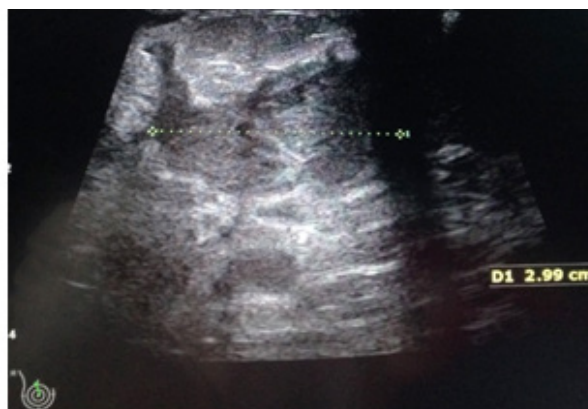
25 year old lady with granulomatous mastitis. Sonography shows an irregular lesion with hypoechoic band like extensions. Note the extension to subcutaneous region.
